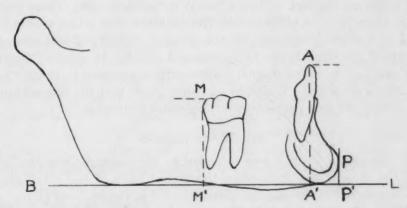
Changes in positions of permanent mandibular first molars and the most anterior incisor were measured on the tracings of the serial cephalometric roentgenograms as follows: horizontal position of molar = M' - P' along base line B - L; of incisor = A' - P'; vertical position of molar = M - M'; of incisor = A - A'.
